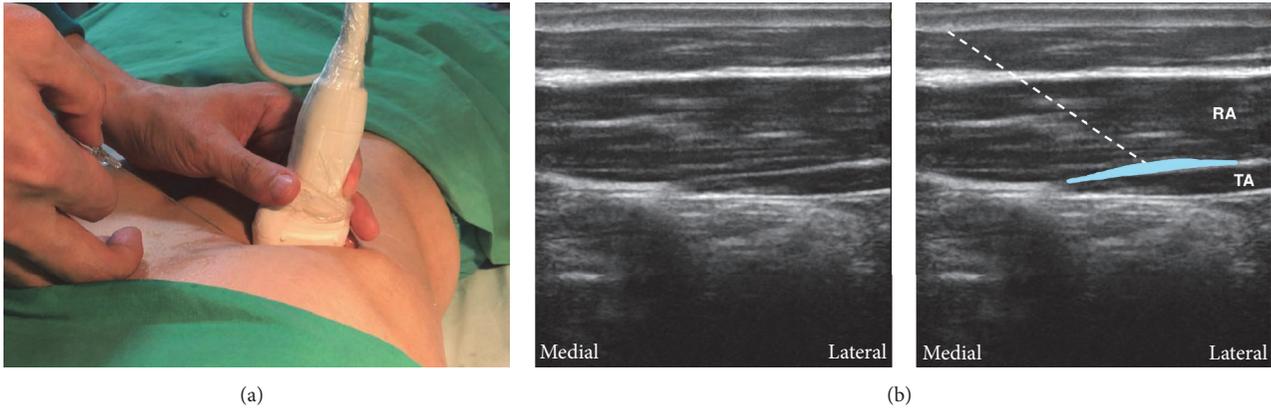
Subcostal approach of transversus abdominis plane (TAP) block. (a) The probe position and needle direction. The probe is parallel to the costal margin near the xiphoid. The needle is inserted in plane. (b) The corresponding ultrasound images. The TAP is between rectus abdominis and transversus abdominis, and the local anesthetic is deposited in this plane to cover the upper TAP plexus. White dashed line: the needle trajectory. Light blue area: the deposition sites of local anesthetic. RA: rectus abdominis; TA: transversus abdominis.
